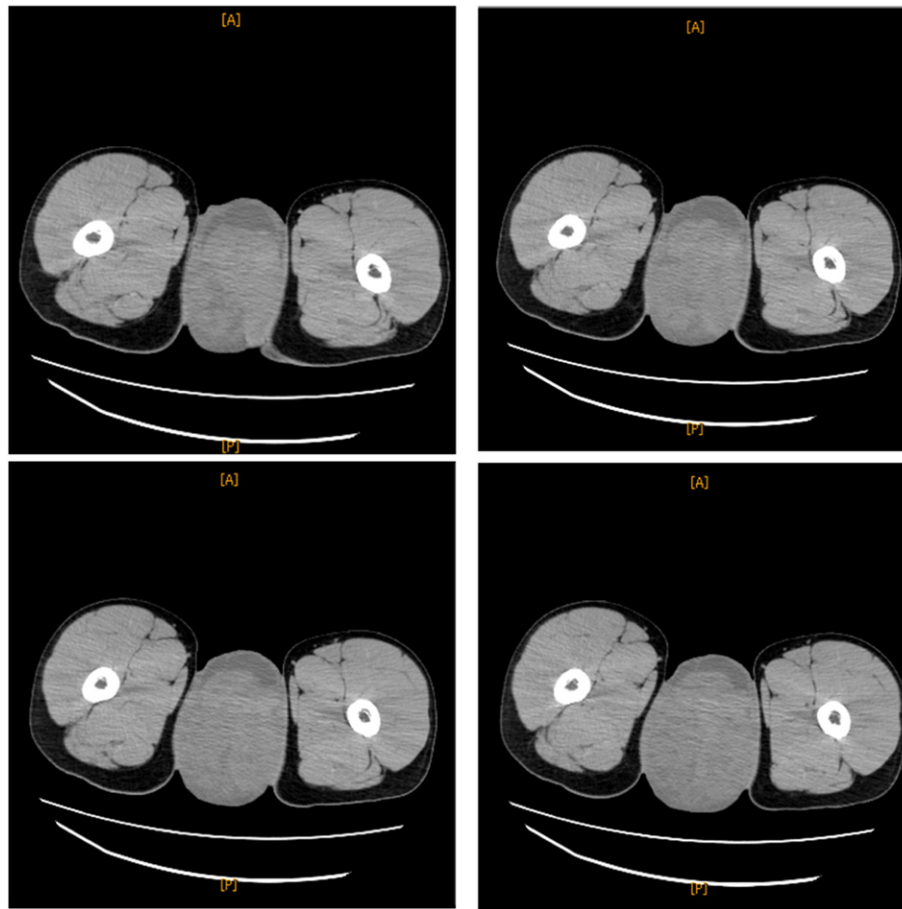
A) The CT pictures of the root part of giant tumor, where yolk sac and embryonal carcinoma components were included. Clover like shades appeared in this lesion.
